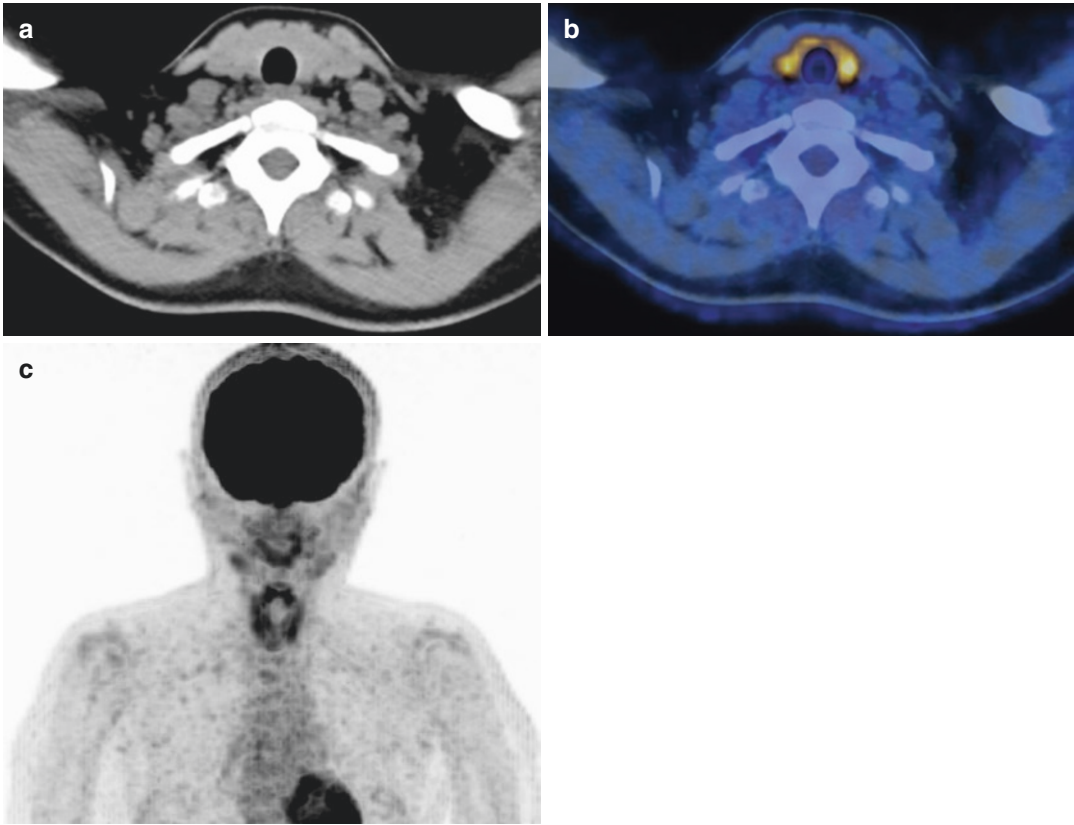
(a–c) Diffusely increased ^{18}F -FDG uptake in thyroid of 53-year-old woman referred for evaluation of melanoma. Patient is taking Levothyroxine 50 mcg/d. TSH 2.03 mU/L, TPO- and Tg-antibodies were elevated at 649 U/mL (reference range, <60 U/mL) and 66 U/mL
